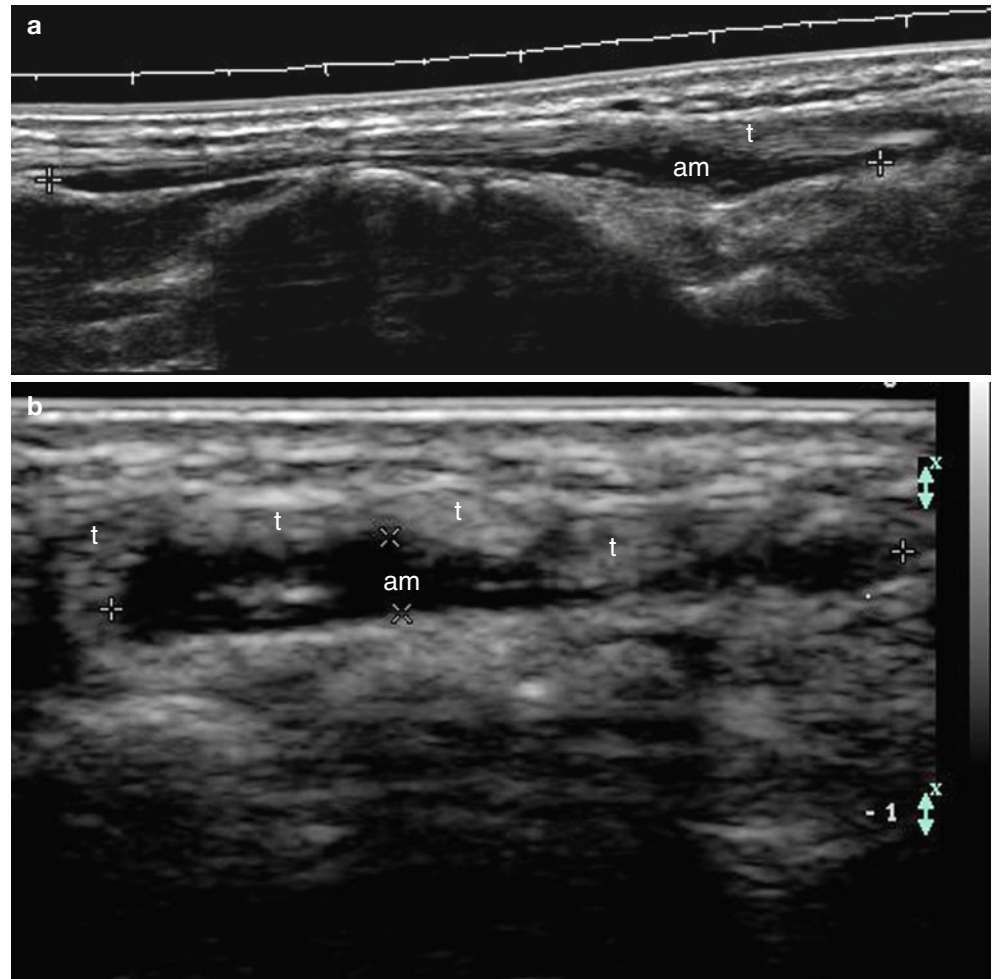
(a, b) Accessory muscle. (a) Ultrasound of the dorsum of the wrist and hand (longitudinal panoramic view). The hypoechoic structure (*am*) attached to the common extensor tendons (*t*) corresponds to an accessory muscle (extensor digitorum brevis manus). (b) Ultrasound of the same dorsum of the wrist and hand in transverse view)
